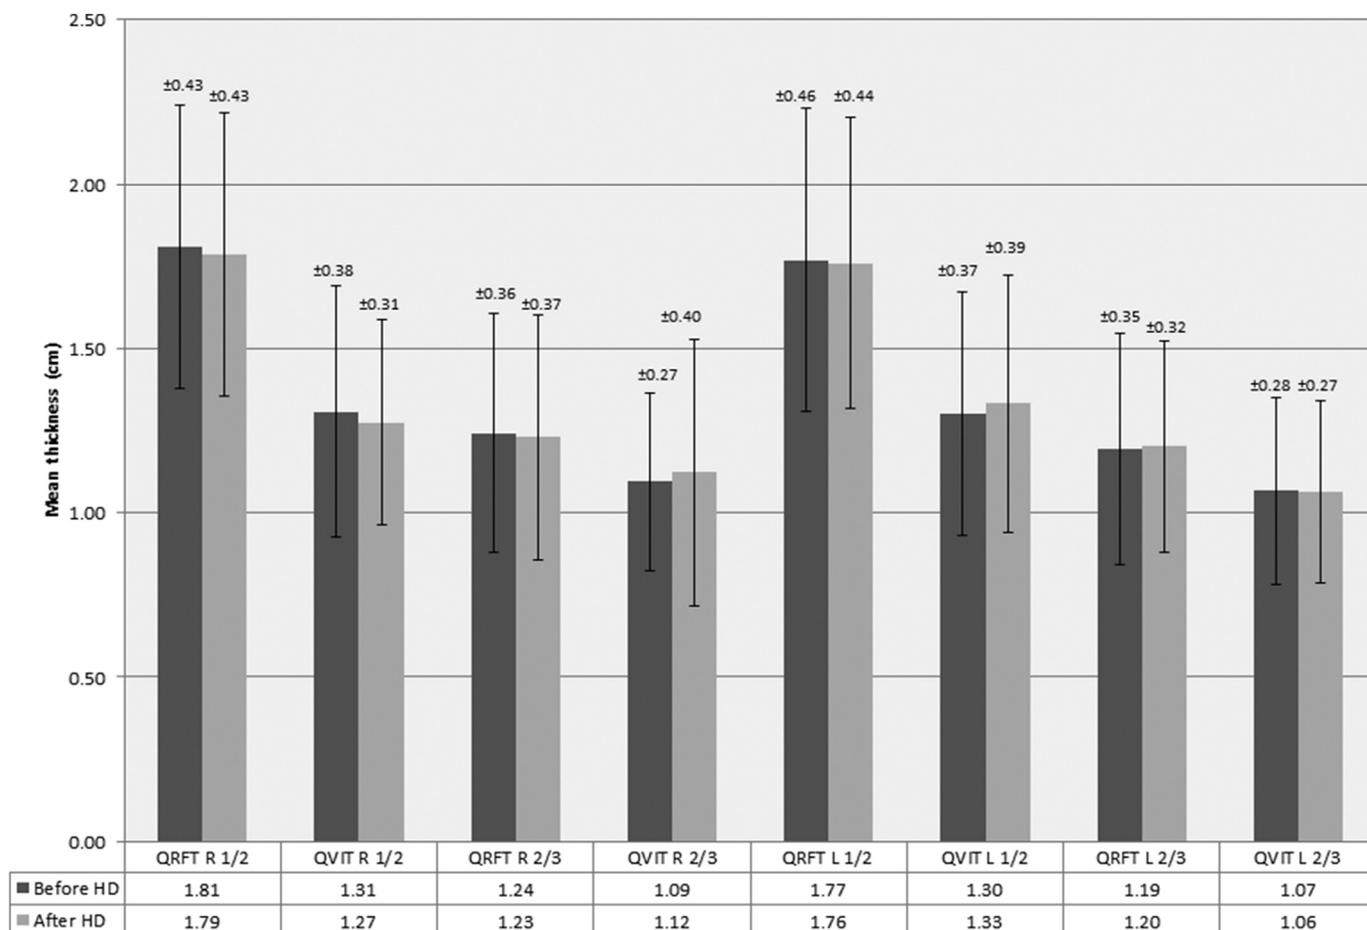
Comparison between US measurements performed before and after the HD session. Data are expressed as mean and standard deviation. No significant difference was found between measurements. HD, hemodialysis; US, ultrasound.
